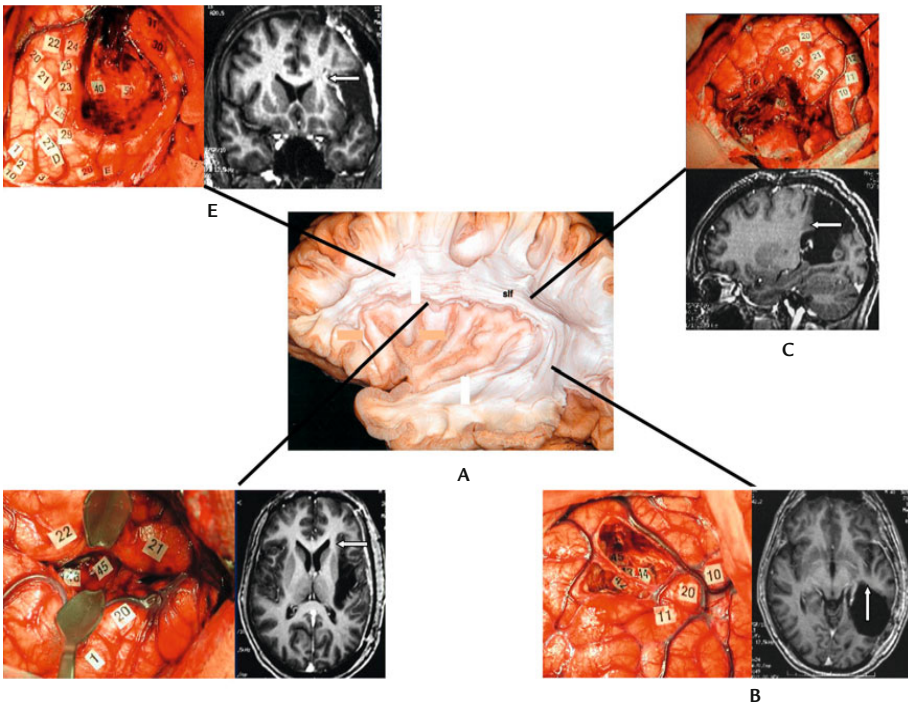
Arcuate fascicle: dorsal phonological stream. (A) Anatomical trajectory of the white matter of the superior longitudinal fascicle (*slf*) studied by dissection. (B–E) Surgical field and postsurgical MRI from different patients operated on for a low-grade glioma at various brain locations: temporal (B), parietal (C), insular (D), frontal (E). In all cases, the deep functional boundary of the resection was given by a part of the arcuate fascicle identified by subcortical mapping. Electrostimulation of this tract systematically induced phonemic paraphasia. The precise locations where these language disorders were elicited were marked intraoperatively by number tags in the depth of the cavity. These sites are shown by an arrow on the postoperative anatomical imaging (Reproduced from [34])
